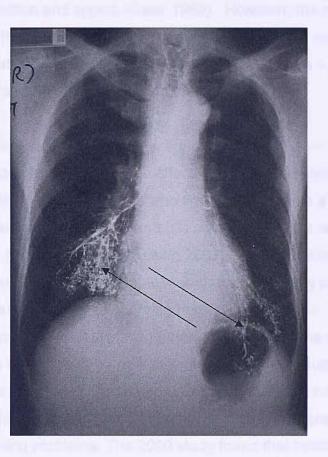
AP view x-ray of thorax demonstrating aspiration – arrows point to barium aspirated into the bronchial tree
